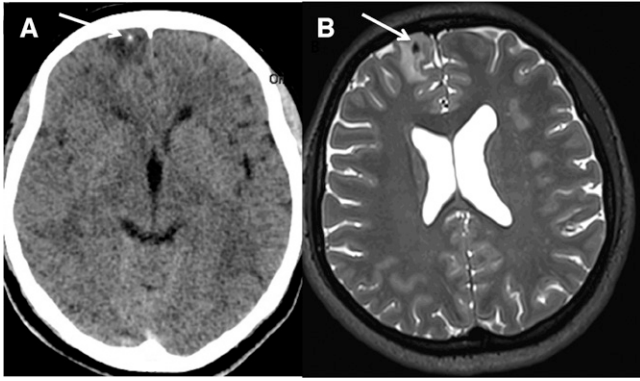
(A) A computed tomography (CT) image showing a calcified lesion in the right frontal lobe with surrounding edema as indicated by the arrow. (B) The corresponding T2 weighted magnetic resonance imaging (MRI) image showing a void, which is a calcification as shown by the arrow and surrounding edema.
